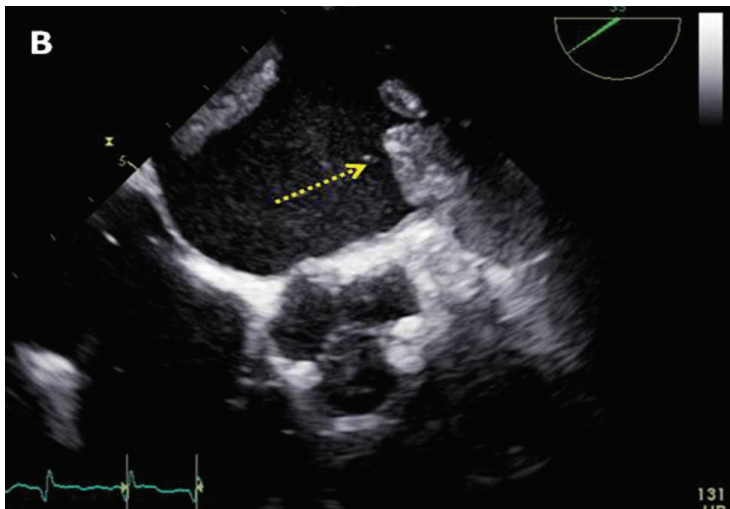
Trans-oesophageal echocardiography (TOE) confirms the presence of a large homogenous mobile mass in a dilated left atrium coming from the left atrial appendage.
